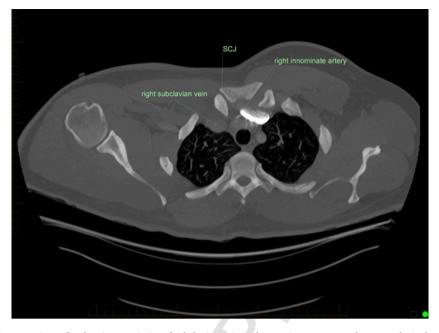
CT angiography showing proximity of subclavian vein and innominate artery to the sternoclavicular joint.
